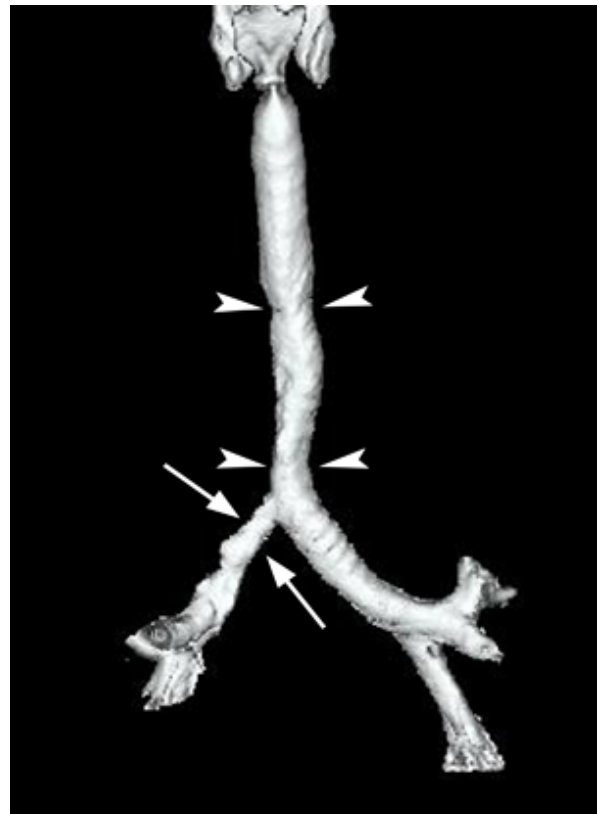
Anteroposterior view of 3D reconstruction CT shows improved right main bronchial (arrows) and tracheal stenosis (arrowheads).
